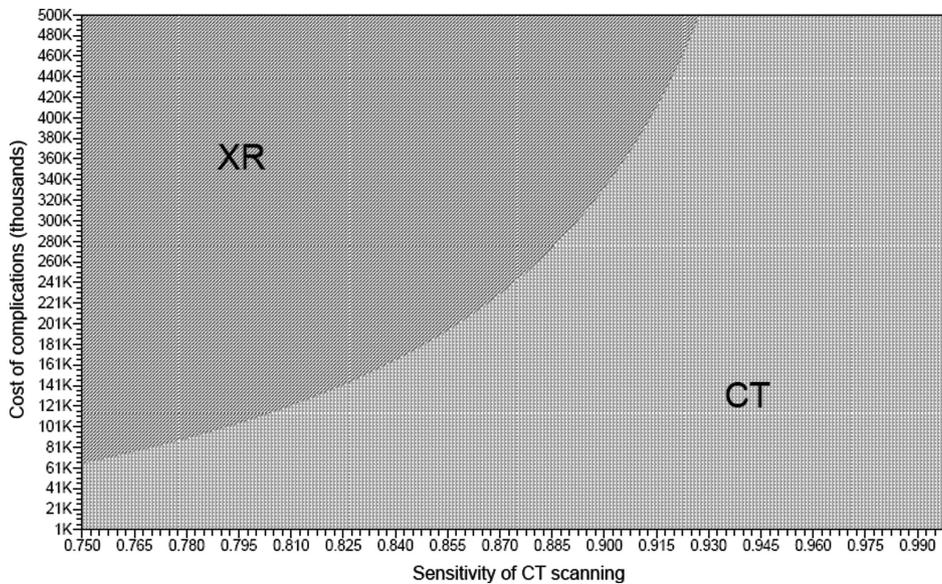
Two-way sensitivity analysis varying cost of complications against sensitivity of CT scanning. This analysis uses sequential decision tree (Fig. 2). Most cost-effective strategy is labeled: XR = plain radiography; CT = computed tomography.
